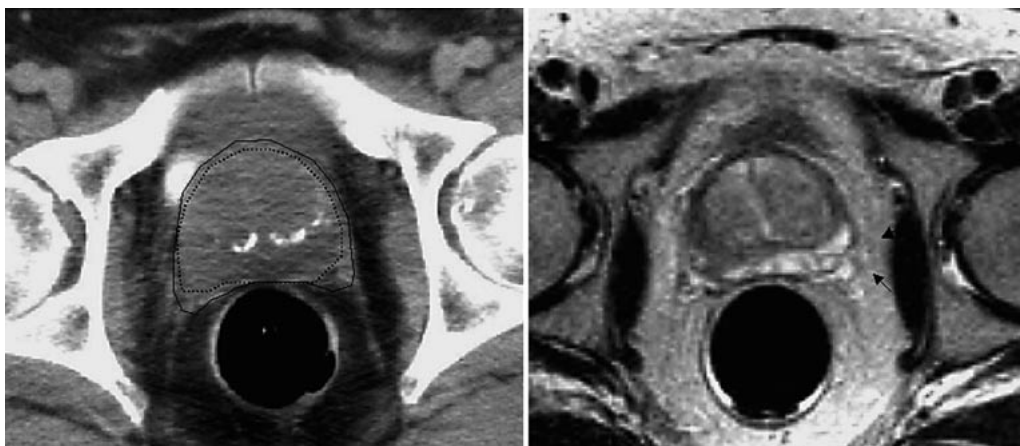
Axial CT image (left) and axial T2-weighted MRI image (right). As indicated (→) the periprostatic tissue and the prostatic capsule can only be identified on the MRI image, leading to an overestimation of prostate volume on CT. Transfer of MR contour (dotted line) to corresponding CT contour.
